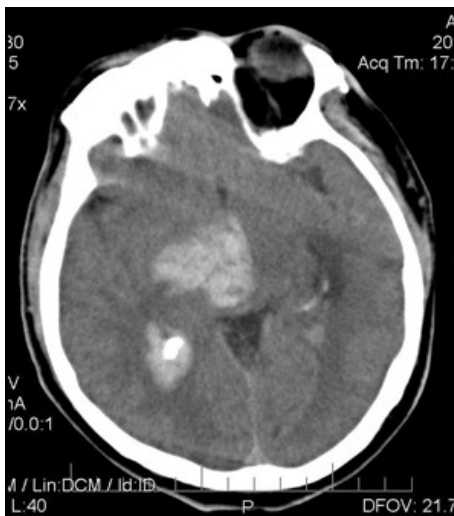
A, B: Native CT showing a large right-sided intracranial hematoma
